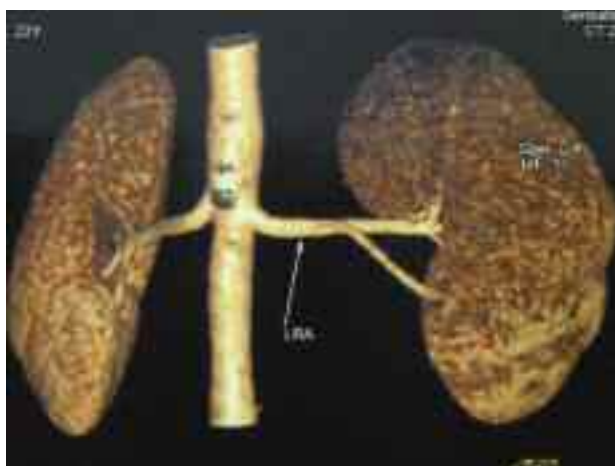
CT angiography of donor kidney. Lower pole of the left kidney was supplied by a polar artery. It was damaged during engraftment.
